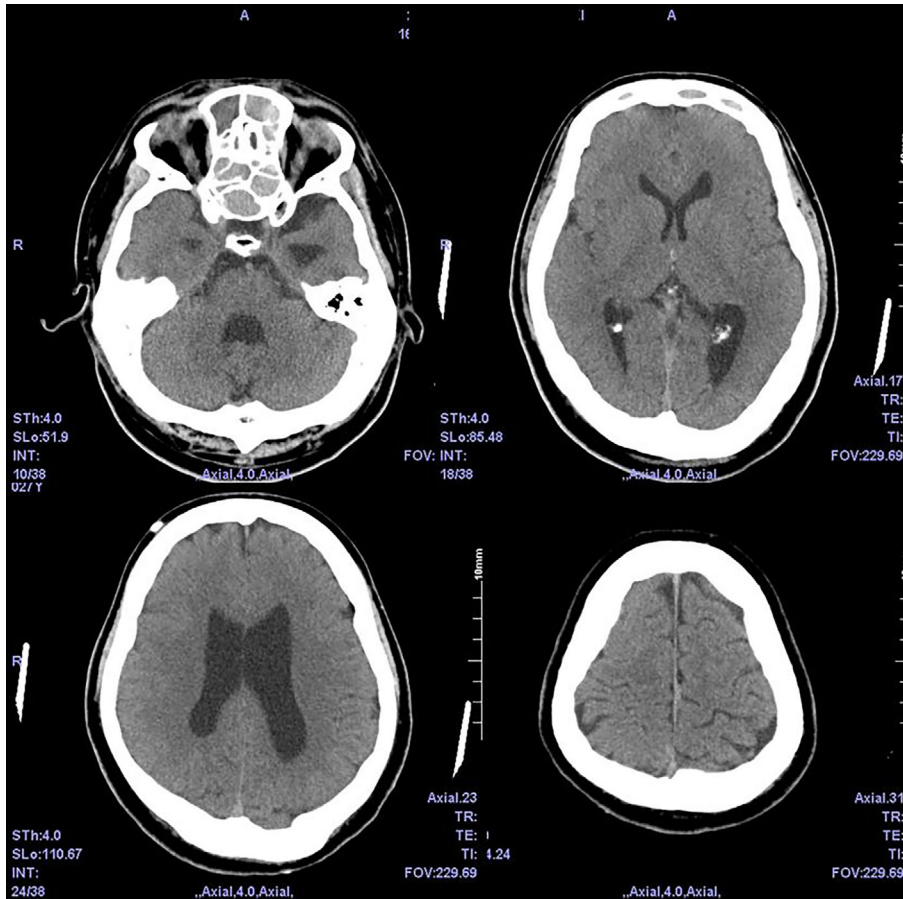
Computed tomography of the patient. Although dilation of the lateral ventricles and the fourth ventricle were found, no cortical dysplasia was observed.
